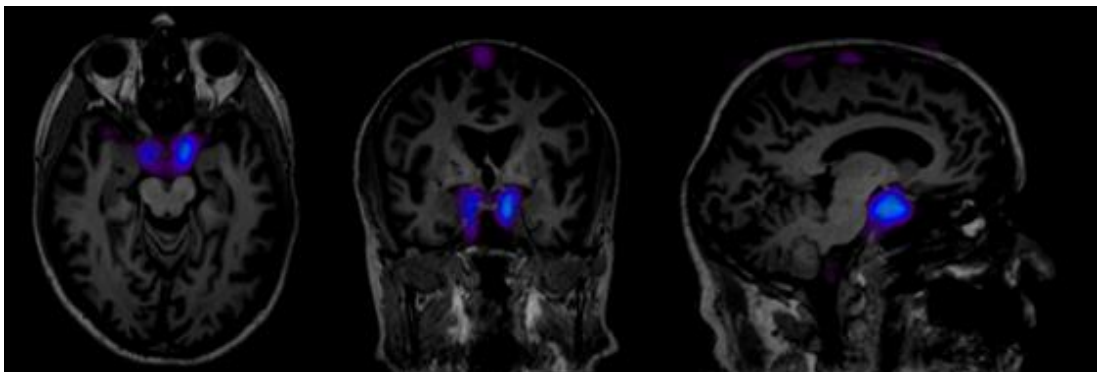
Parim Generated in AMIDE Representing VB Co-Registered with MRI Scan.
